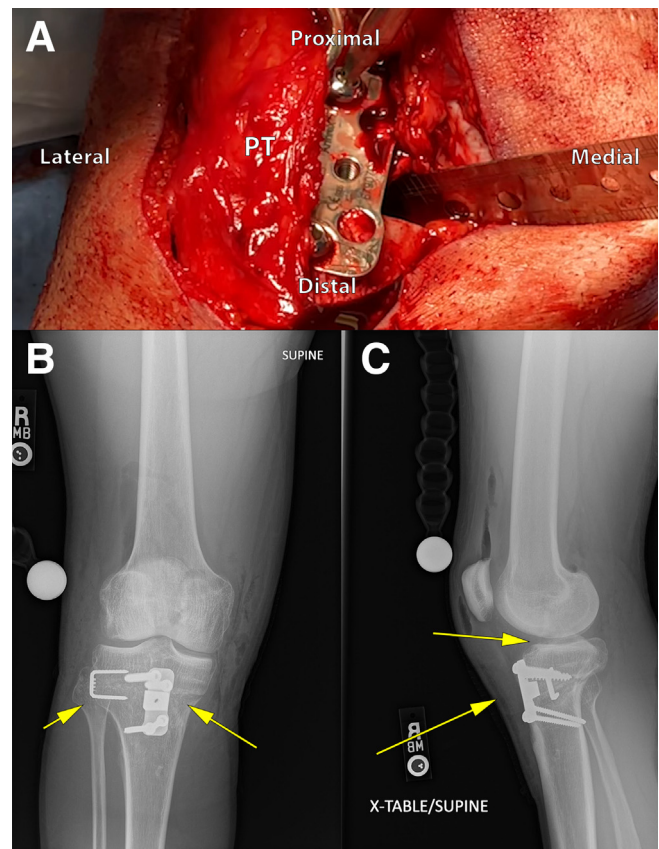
(A) A posteriorly sloped Puddu plate is placed just medial to the patellar tendon and fixed proximally with 2 cancellous screws and distally with 2 cortical screws. (B) Anteroposterior radiograph of the right knee showing appropriate placement of Puddu plate and anterolateral large Richards staple. (C) Lateral radiograph of the right knee confirming proper placement of Puddu plate and correction of anterior tibial slope. In these radiographs, it is evident that the tibial slope has been corrected, resulting in elimination of genu recurvatum and posterior tibial translation. PT, patellar tendon.
